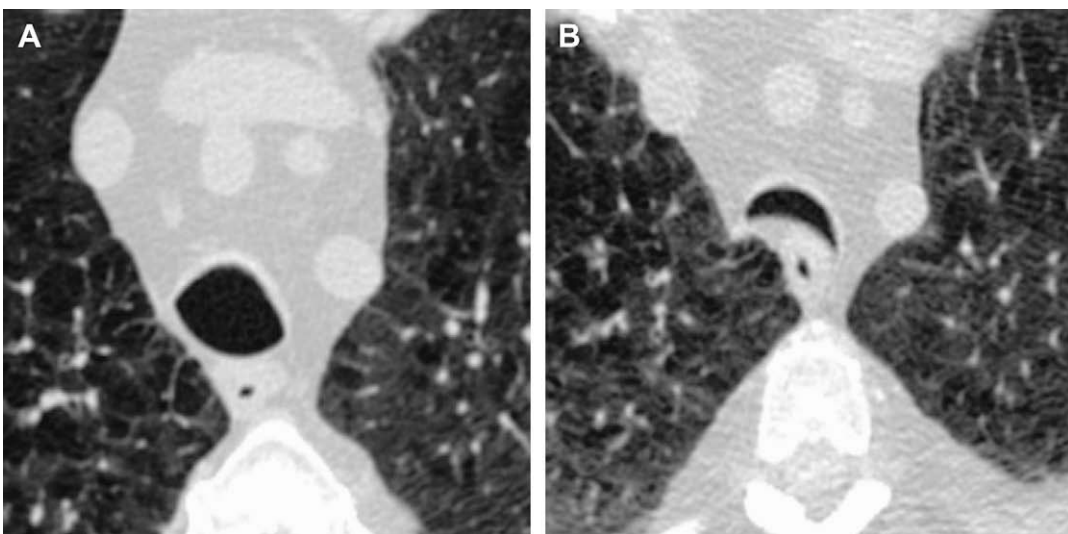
Lunate configuration of the trachea in a 71-year-old woman with chronic cough and dyspnea. End-inspiratory CT image (A) demonstrates widening of coronal diameter of trachea with respect to the sagittal diameter, consistent with a lunate configuration. Dynamic-expiratory CT image (B) shows excessive expiratory collapse of airway lumen, consistent with TM.
